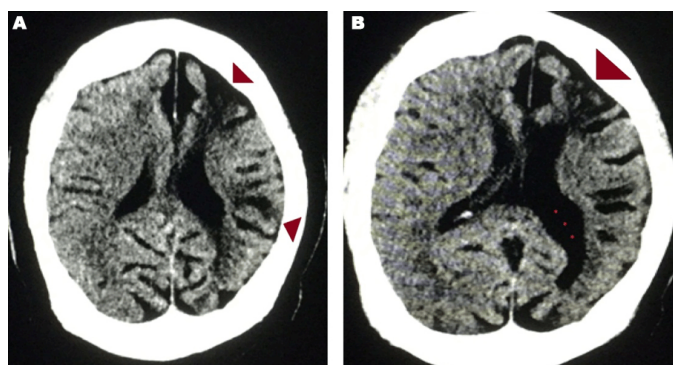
(A) Demonstrates left sided Fronto-Temporal cerebral atrophy with widening of sulci and atrophy of gyri as shown by red arrow heads. (B) MRI demonstrates left sided Fronto-Temporal cerebral atrophy (red arrow heads) along with significant left ventricular dilatation without midline shift as shown by red asterisks.
